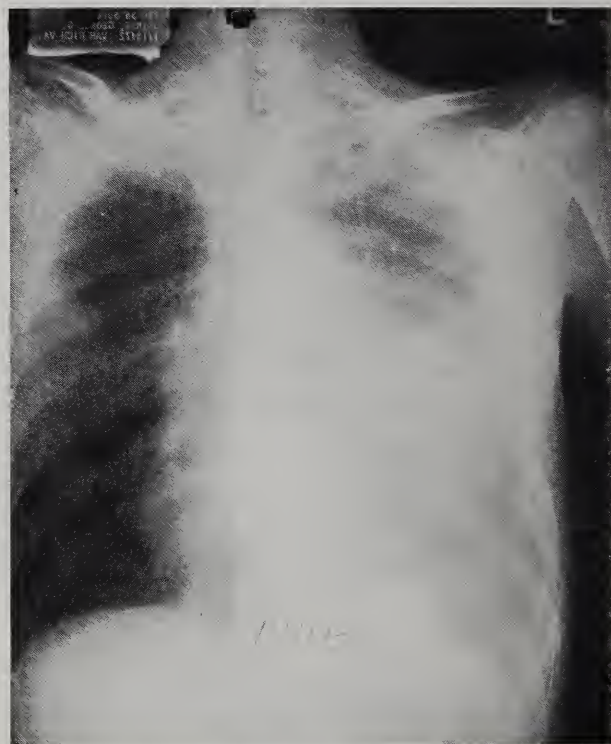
PA and lateral chest x-ray showing a rounded density just behind the anterior ribs and persistent pleural effusion.
